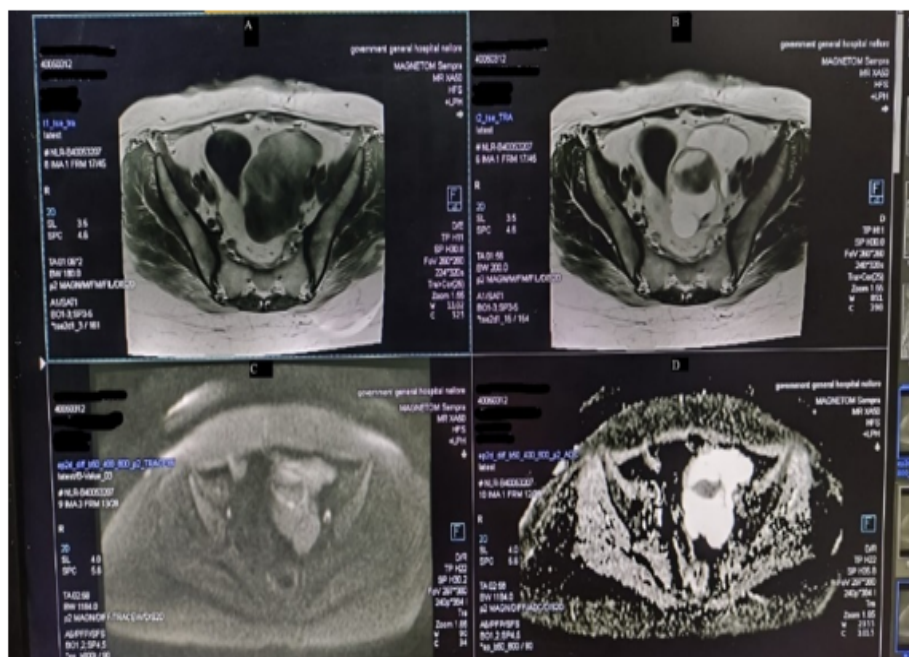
A. Axial T1 weighted image of MRI pelvis predominantly hyperintense lesion with intermediate intensity areas within with hypointense thin internal septations. B. Axial T2 weighted image showing well defined multiloculated predominant hyperintense lesion with central intermediate to hypo intensity area with T2 shading thin hypointense internal septations. C. DWI image at b1000 showing patchy Restricted diffusion in the central portion of the lesion. D. ADC image showing predominant facilitated diffusion with hypointensity within the central portion
